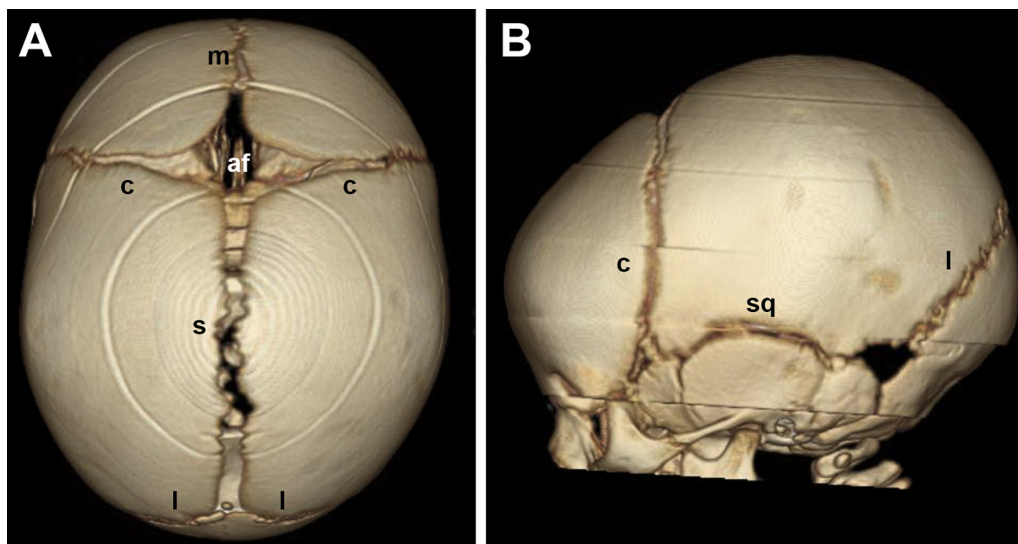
Normal cranial sutures and skull shape. Top (A) and side (B) views of a three-dimensional computed tomography scan shows metopic (m), coronal (c), sagittal (s), lambdoid (l), and squamosal (sq) sutures as well as the anterior fontanel (af). (The color version of this figure is available in the online edition.)
